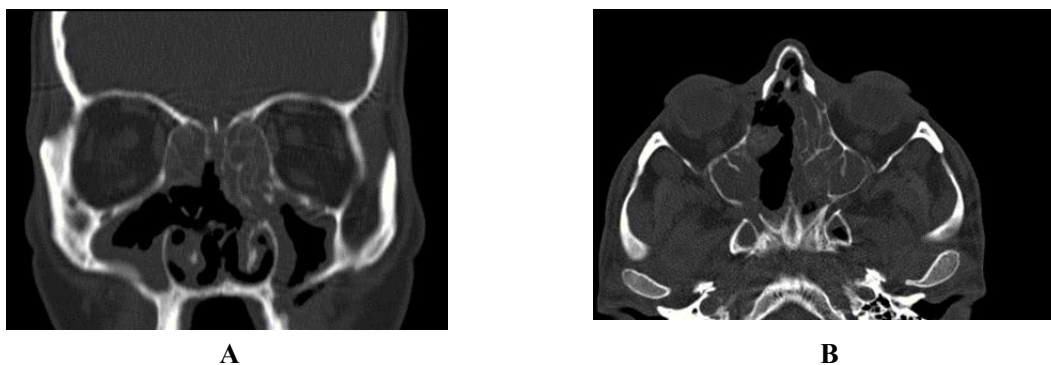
Axial (A) and coronal reconstructed (B) CT images of the paranasal sinuses show mucosal thickening, destruction of the left medial maxillary sinus wall and nasal septum perforation
